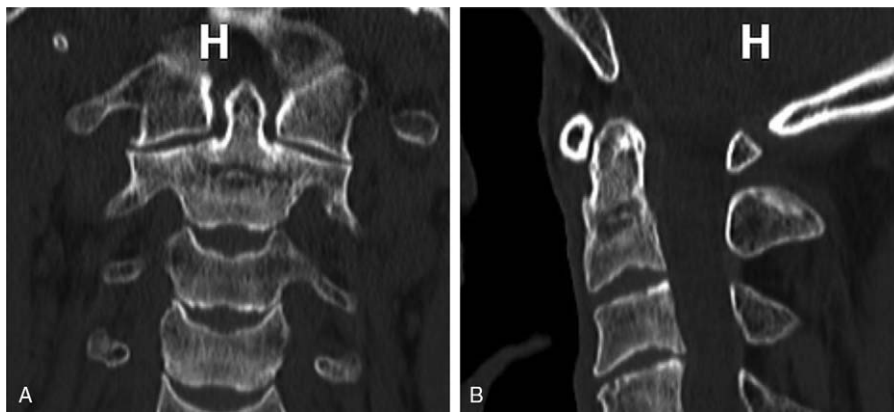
At the 6-month follow-up, two-dimensional reconstructed CT scans (A and B) showed a well reduced state of C1–2 and union processing of type III dens fracture and bilateral articular facet fractures of C2. CT=computed tomography.
